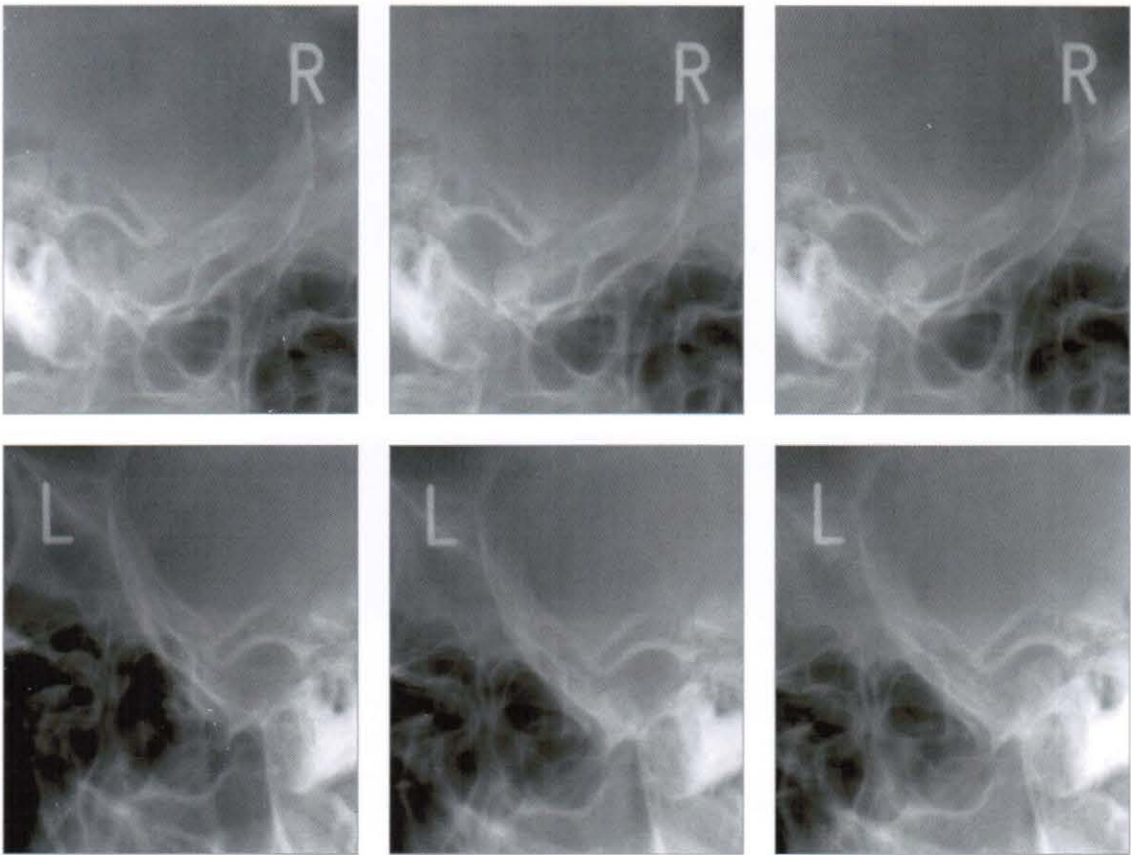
Transcranial radiograph (2005, 228)
